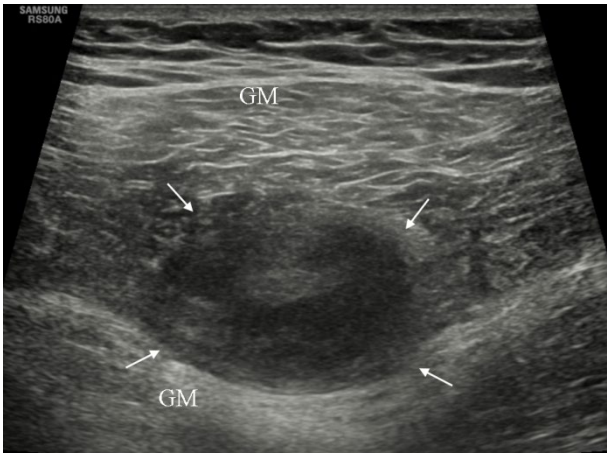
Right gluteal metastasis revealed by ultrasound
